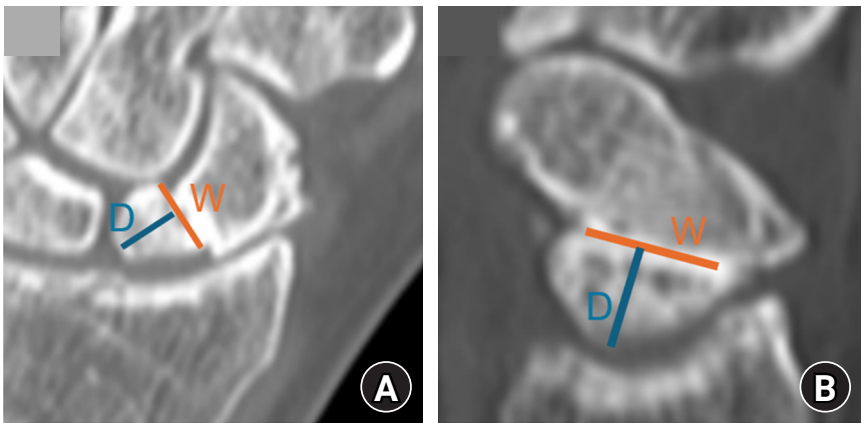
Computed tomography-based assessment of proximal fragment dimensions. (A) Width (W) and depth (D) measured on the reconstructed coronal image using the section in which the proximal fragment appeared longest. (B) Width (W) and depth (D) measured similarly on the reconstructed sagittal image using the section in which the proximal fragment appeared longest. Depth was defined as the distance from the nonunion line to the proximal subchondral boundary in the intended distal-to-proximal screw direction.
